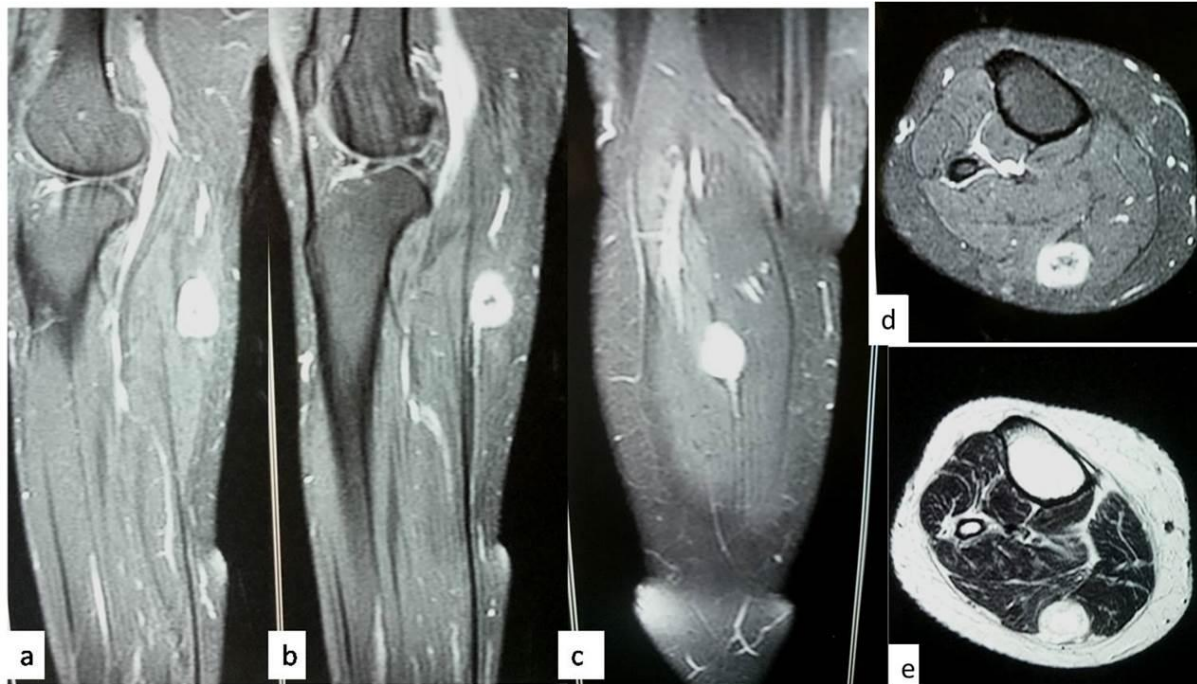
a,b,c) On Sagittal MRI Schwannoma can be seen in relation to nerve and surrounding structures
